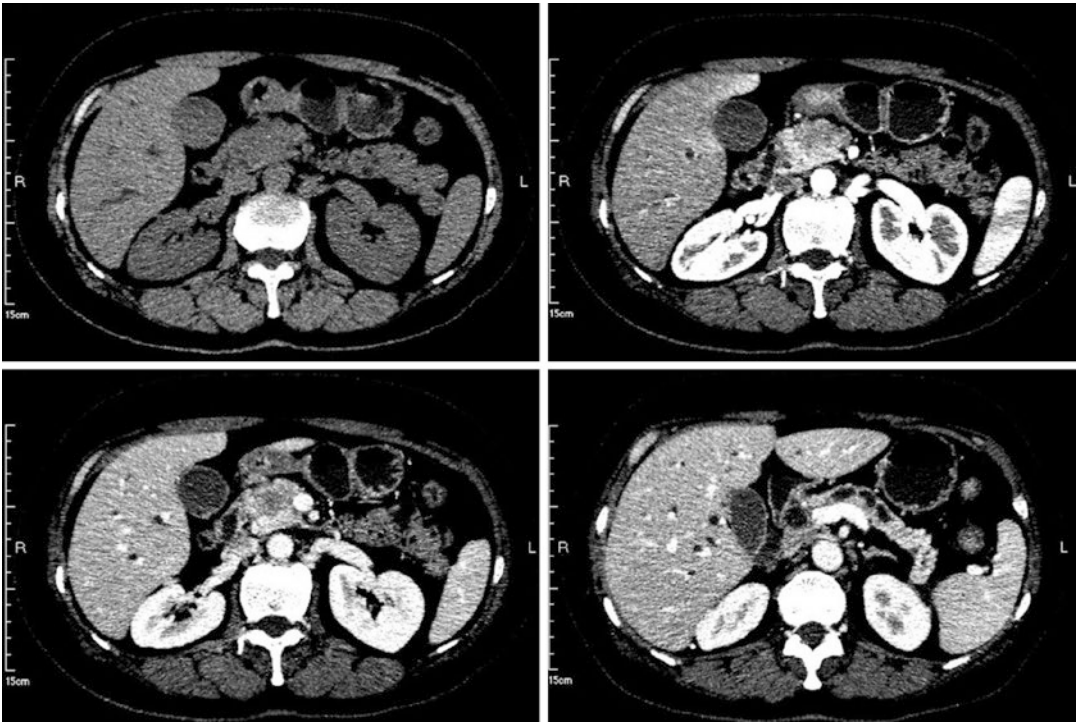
CT images demonstrate an infiltrative, low attenuation mass involving the head of pancreas causing obstruction of the distal pancreatic duct and atrophy of the pancreatic parenchyma
